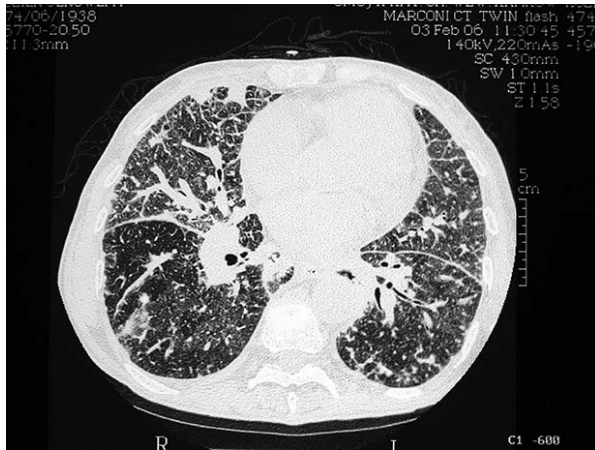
The HRCT scan with thickening of septal lines, areas of alveolar opacities and symptoms of alveolar and interstitial oedema
